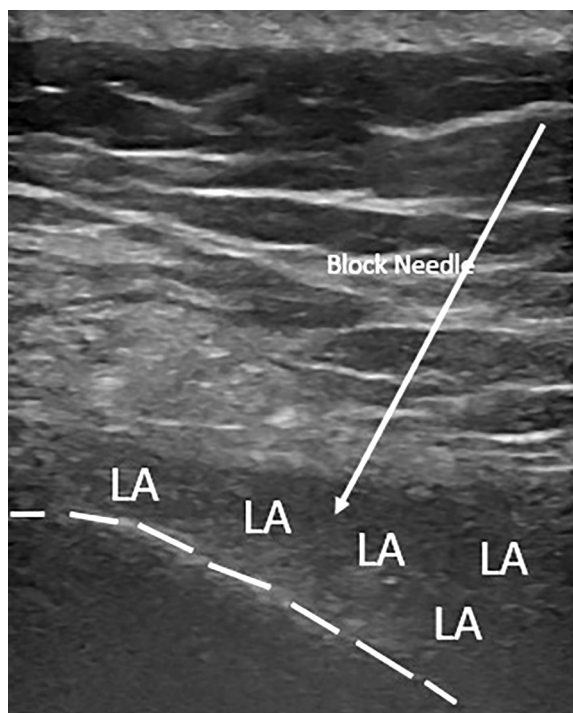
Ultrasound image of median approach sacral erector spinae plane block, white arrow represents the block needle and the point of injection.
